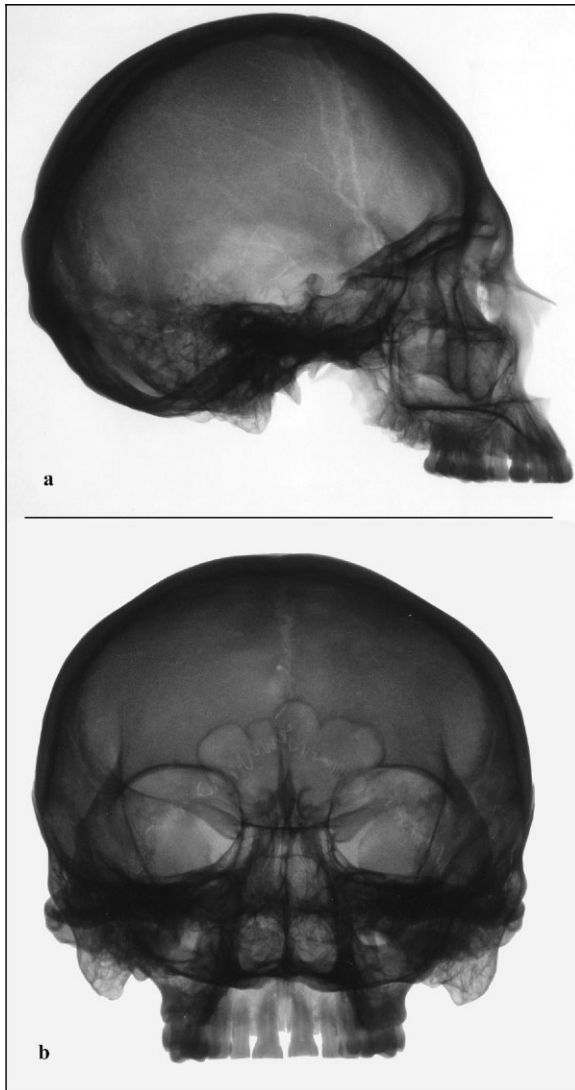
(a) Medial-lateral and (b) anterior-posterior radiographs of Motmot's cranium.
